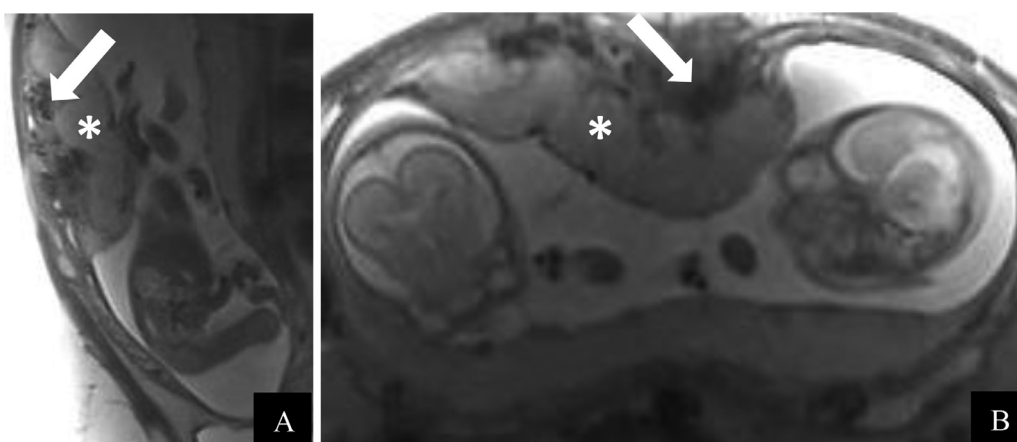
Sagittal (A) and axial (B) single shot turbo spin echo T2-weighted images of the abdomen demonstrating lobular and minimally heterogeneous anterior placenta (asterisk) with increased sub-placental flow voids (arrows).
